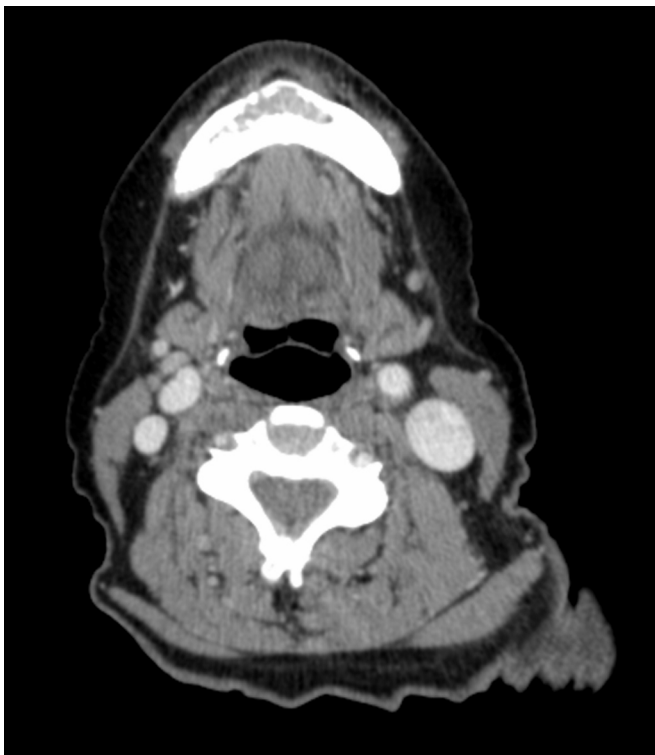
CT scan - Transversal section: osteolytic lesion in the anterior region of the mandible, and significant thinning of the cortical bone.
